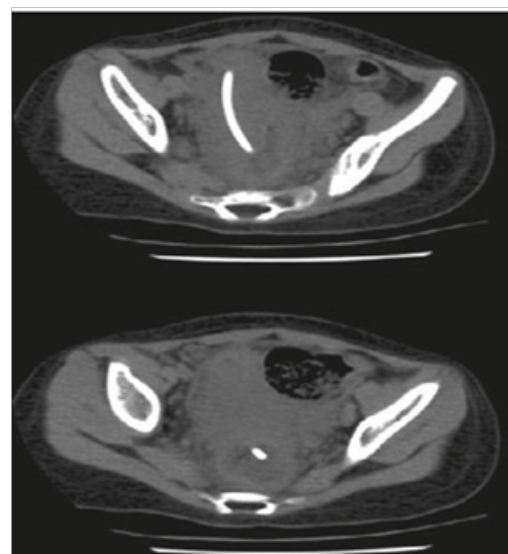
Coronal sections of abdominal computed tomography showing distal catheter penetrating into the rectum.
